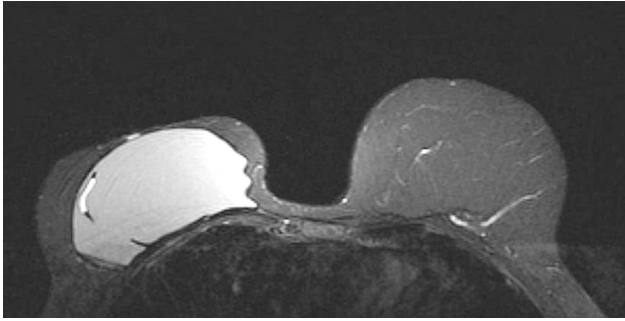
A T2-suppressed MRI showing a hyperdense material within the silicone breast implant. This was later confirmed to be the injected adipose tissue, which presumably has a high water content.
